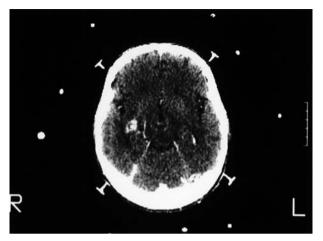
Detail of CT scan target of what proved to be an infective granuloma and not a suspected metastatic brain tumor
